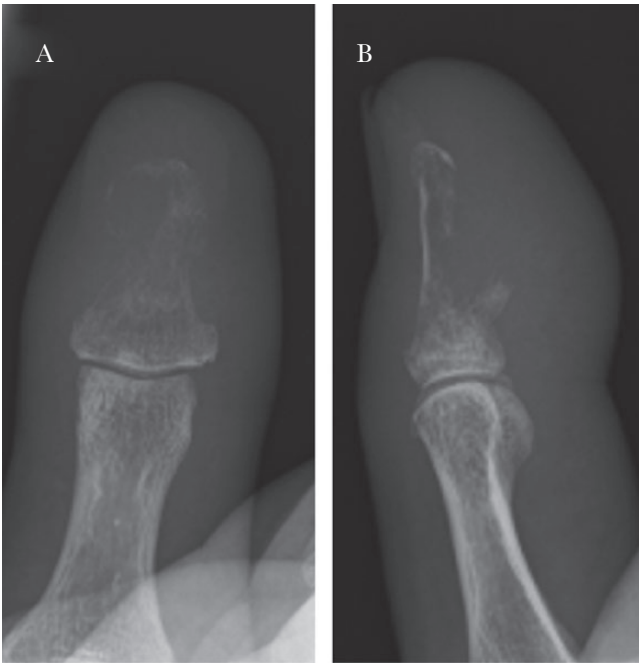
Plain x-ray images of the phalanx of the right thumb at first presentation. A, Frontal view. B, Lateral view.
